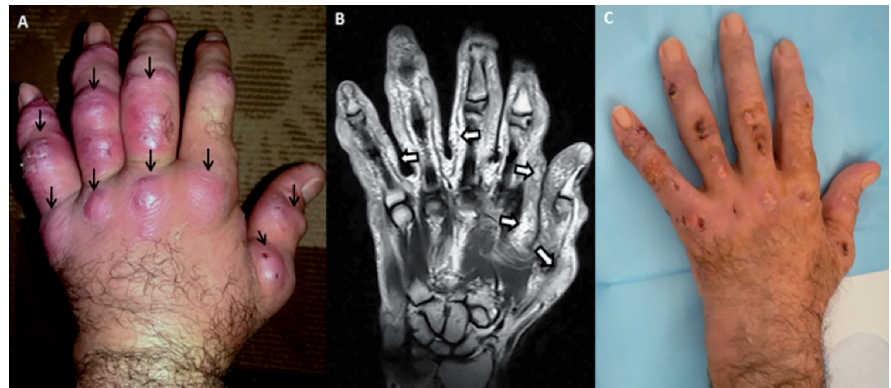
(A) At presentation a diffuse, painful and restrictive swelling of the dorsal and palmar aspects of the left hand was evident, while erythematous nodules (arrows) were noted over all hand joints (B) left hand MRI revealed extensive soft tissue swelling, without bone erosive lesions, and multiple subcutaneous nodules in a sporotrichotic distribution (arrows), (C) marked improvement was achieved after treatment with combination of antibiotic drugs and a short course of oral methylprednisolone.
